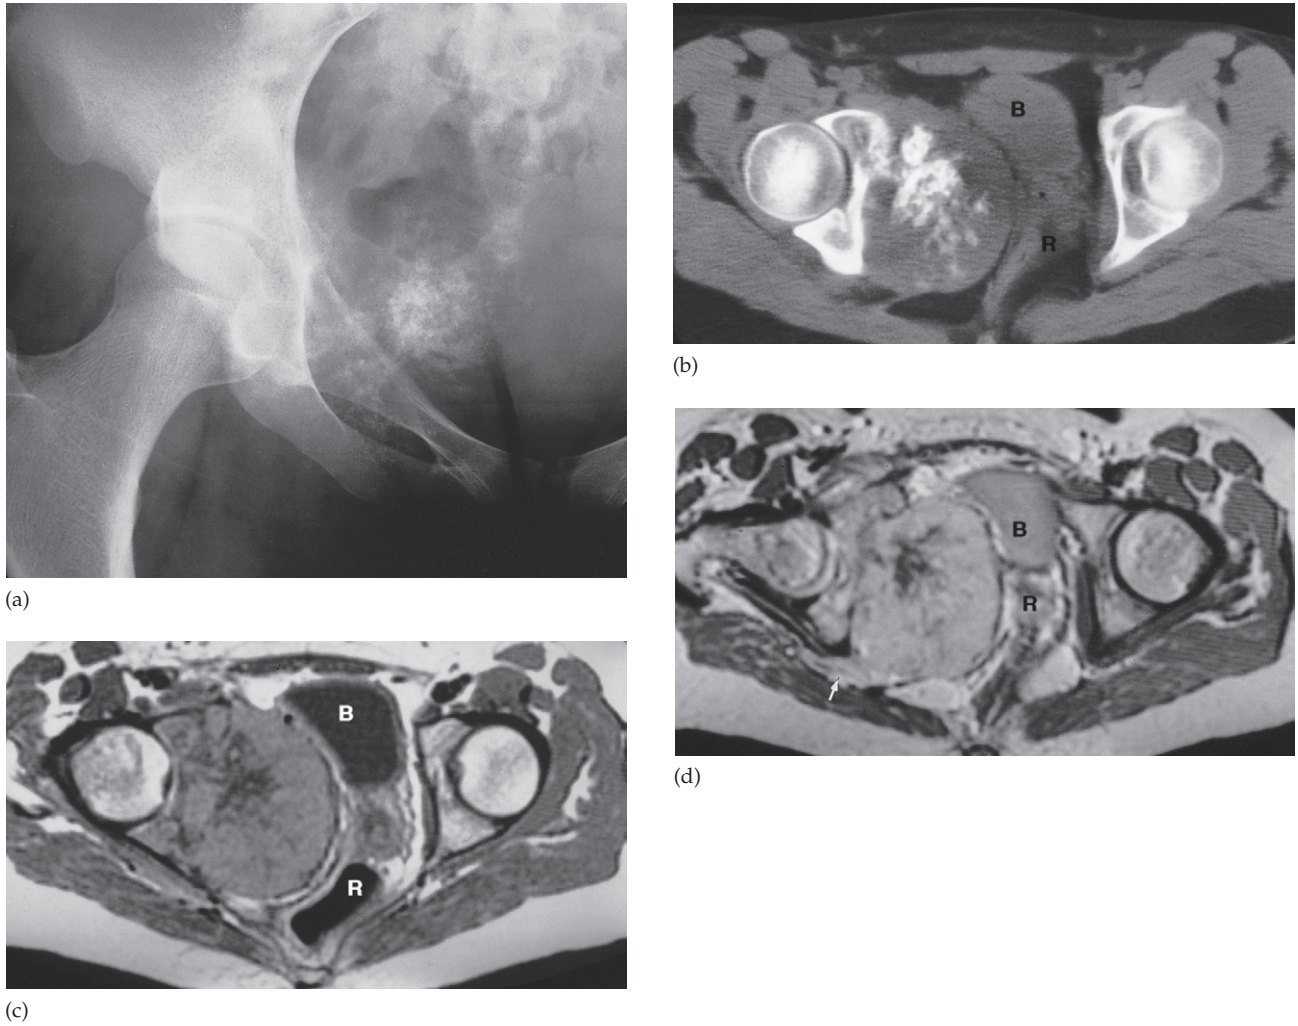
Chondrosarcoma. (a) Plain film showing a large mass containing calcification arising from the pubic ramus. (b) CT showing the large mass containing calcium. There is also displacement of the bladder and rectum. (c) Axial MRI scan at the same level. Note that the calcification gives no signal. (d) MRI scan at a lower level showing the tumour extending into the gluteal muscles (arrow). B, bladder; R, rectum.
